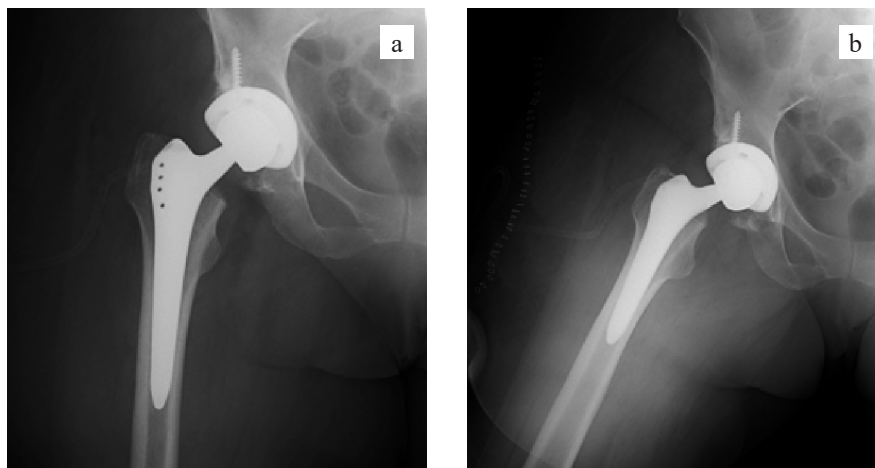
X-ray on the first postoperative day following total hip arthroplasty of the right hip using a Zimmer–Biomet cementless endoprosthesis (IT cup, Alloclassic stem): a, hip joint in neutral position; b, hip joint in abduction position
